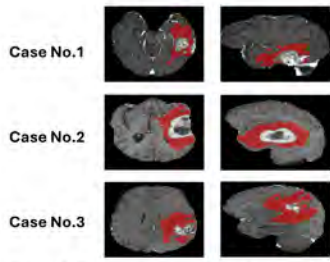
Representative axial and coronal MR images from three patients with glioblastoma. The red mask delineates the peritumoral edema, while the central core represents the contrast-enhancing tumor.
